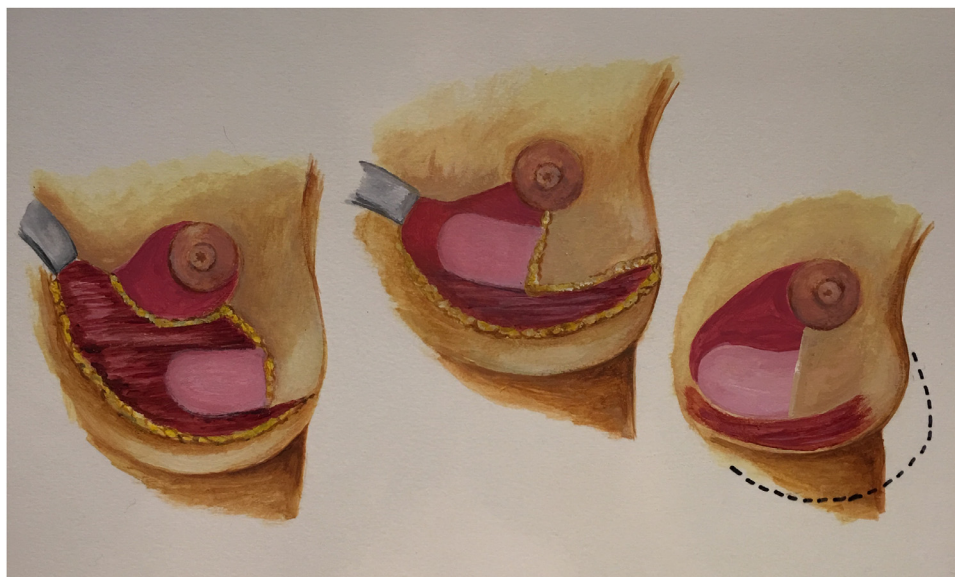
Two flaps are inset with opposite spiral movements, the nipple is transposed to the new position, the LBIP flap is advanced and rotated towards the parasternal line and sutured to the new inframammary fold and the LBIP dermoglandular flap is anchored medially to the pectoral fascia on the parasternal line at the level of the nipple.
